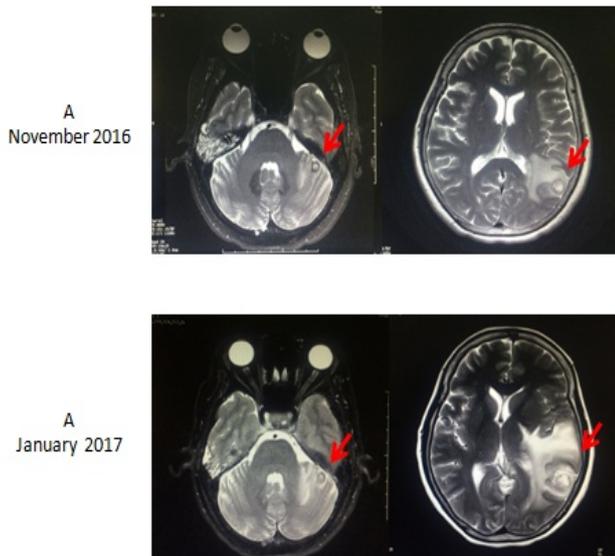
Metastases in the brain which were detected by brain MRI in November 2016 and increased in January 2017.
